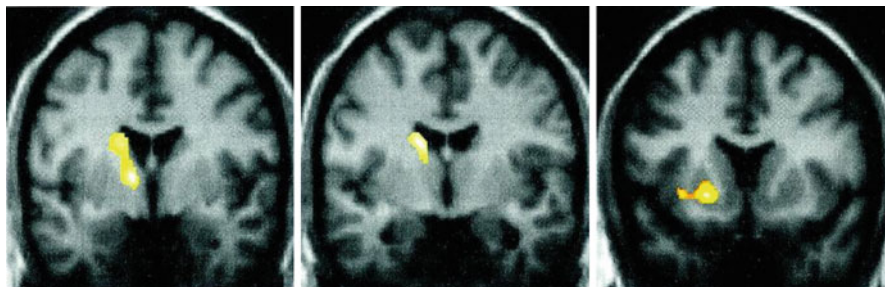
SPECT of four patients with unilateral functional motor and sensory symptoms comparing the symptomatic state to the recovered state. The figures show hypoactivity in thalamus, caudate and putamen (Reproduced by permission from Brain, Vuilleumier et al. (2001))
